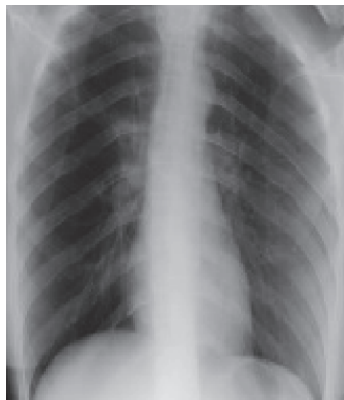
Normal cardiothoracic index; no pleural effusion and clear angles on chest radiograph.
